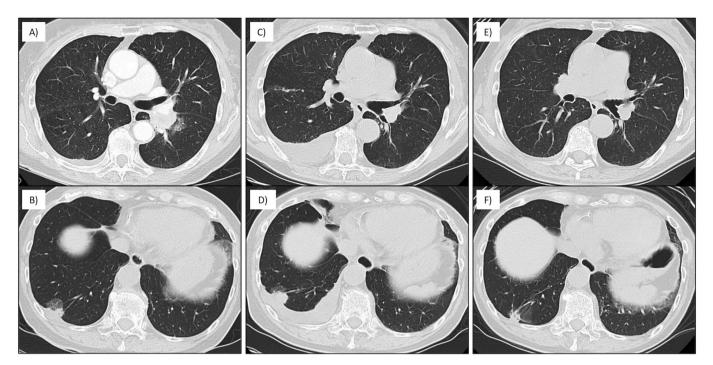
Summary of chest computed tomography findings. At initial diagnosis (A, B), at 15 months after administration of alectinib (C, D) and after 7 months of combination therapy with alectinib and osimertinib (E, F). A 32-mm solid mass in the LLL (A) and a 21-mm mixed ground glass nodule in the RLL (B) were detected at initial diagnosis. After treatment with alectinib, the LLL mass was shrunk (C), the RLL mass was enlarged, and the pleural effusion was increased (D). Combination therapy with alectinib and osimertinib resulted in shrinkage of the RLL mass and decrease in the right pleural effusion (F). LLL, left lower lobe; RLL, right lower lobe.
